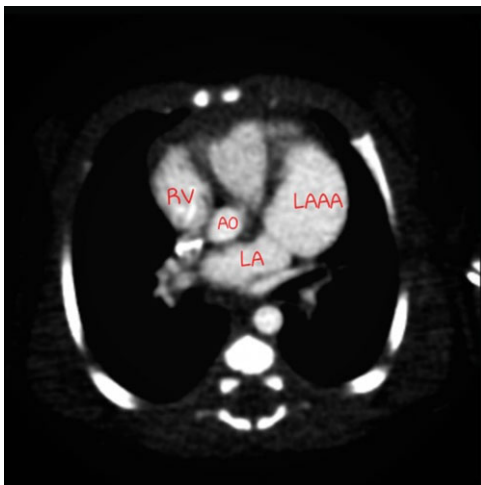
CT angiography image of LAAA for case 2. RV: left ventricle; AO: aort, LA: left atrium; LAAA: left atrial appendage aneurysm.
